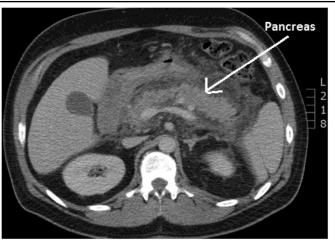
Computerized tomography (CT) of abdomen/Pelvis with IV and oral contrast which demonstrating extensive pancreatic edema, especially involving the pancreatic head and uncinate process, and peripancreatic stranding
